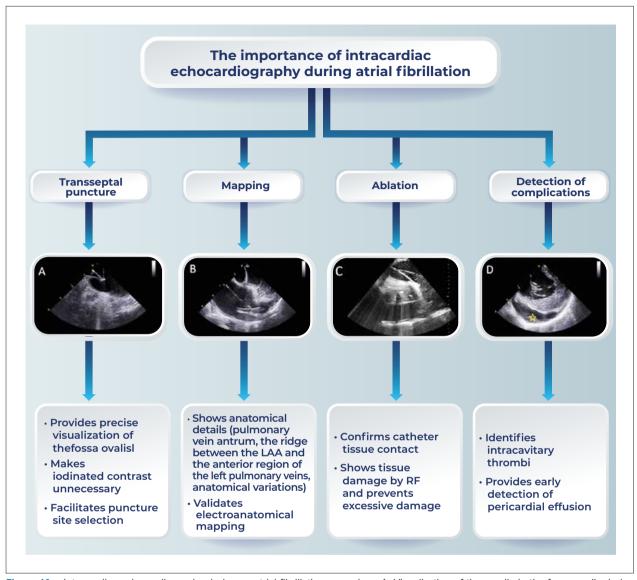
Intracardiac echocardiography during an atrial fibrillation procedure. A: Visualization of the needle in the fossa ovalis during transseptal puncture; B: With the probe positioned in the right ventricle, an image of the left atrium reveals the left atrial appendage and the ridge between the left atrial appendage and the anterior region of the left pulmonary veins; C: RF application near the left inferior pulmonary vein. Hyperreflective tissue adjacent to the catheter indicates effective application, so the catheter should be moved to another area to avoid excessive injury; D: Pericardial effusion is identified by positioning the intracardiac echocardiography probe in the right ventricle at the beginning of the procedure. The procedure was safely performed by comparing images captured at the beginning and end of the ablation. RF: radiofrequency.
